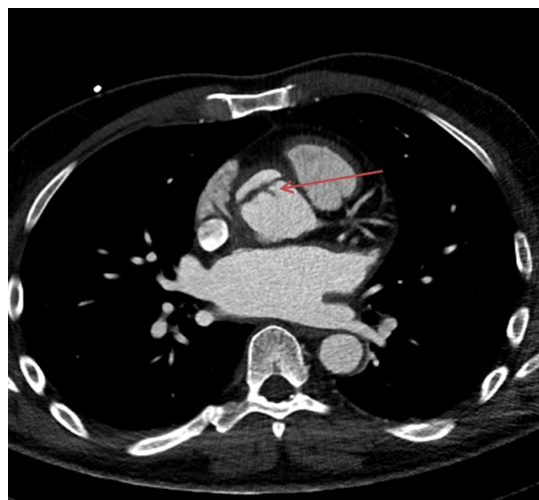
Chest CT Scan, the intimal flap marked by the arrow, marking the pseudoaneurysm.
